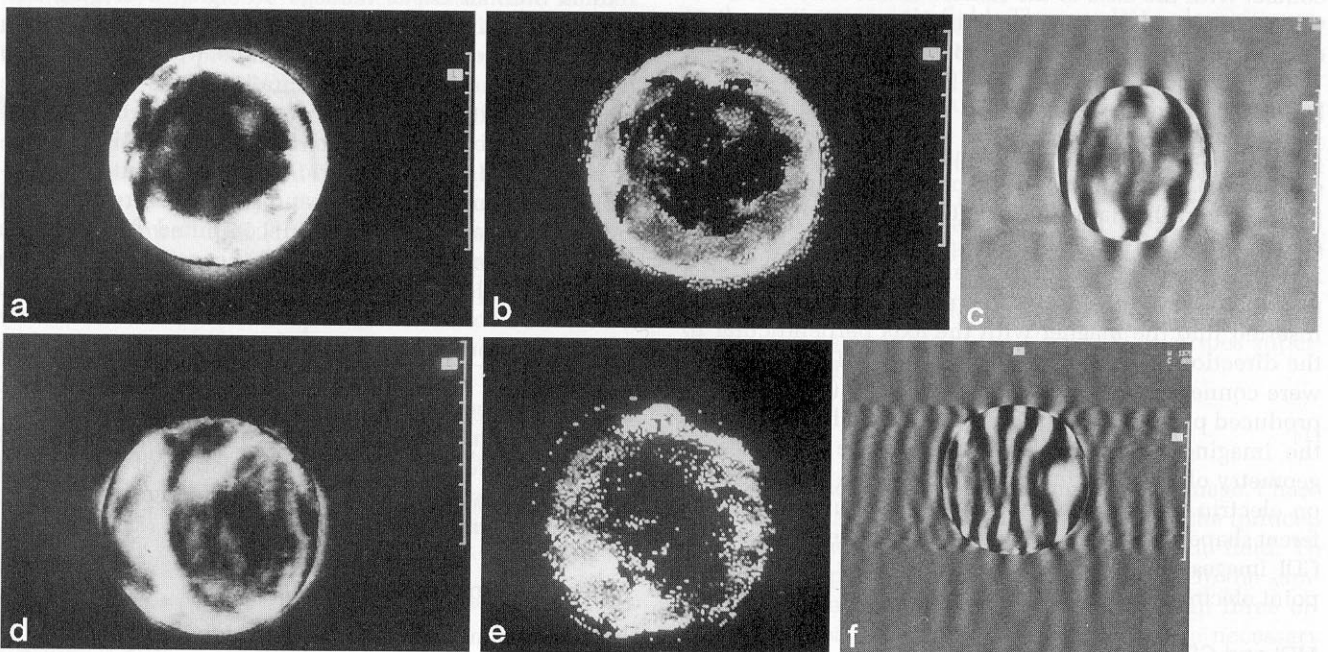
In vitro* CDI data from symmetric (upper row) and nonsymmetric (lower row) SA-1 sarcoma ((a) and (d) represent conventional MRI, (b) and (e) CDI from two orientations, (c) and (f) real component of the signal in x axis).
